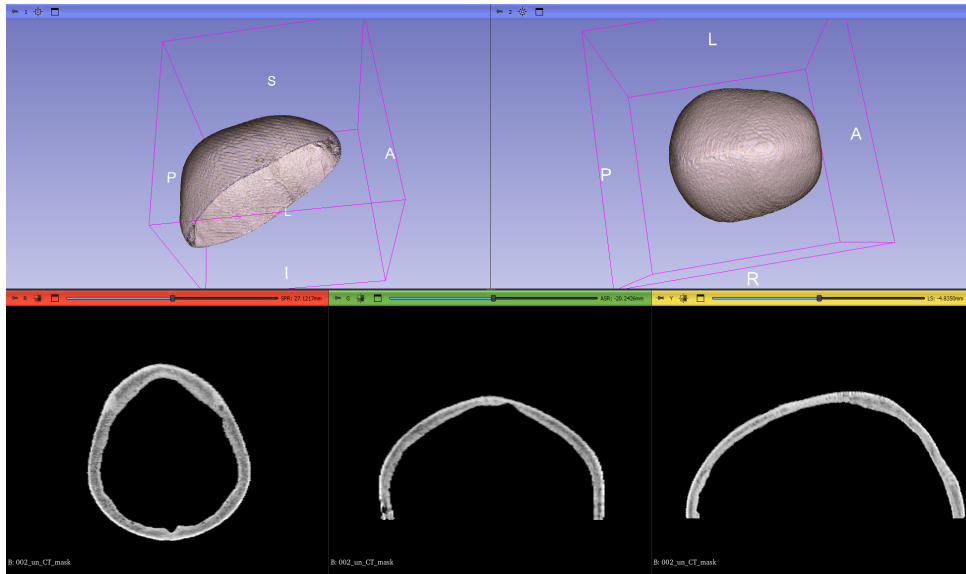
An example of the created 3D calvaria mask volume of one unconventional CT image. Distal, dorsal, and medial views in the lower part, respectively.
